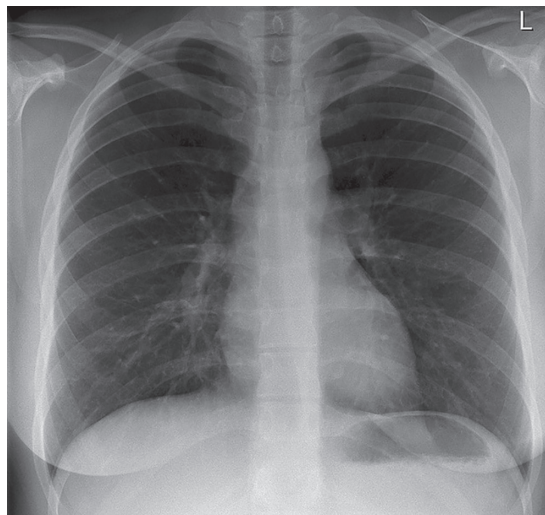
X-ray chest: Posteroanterior view
